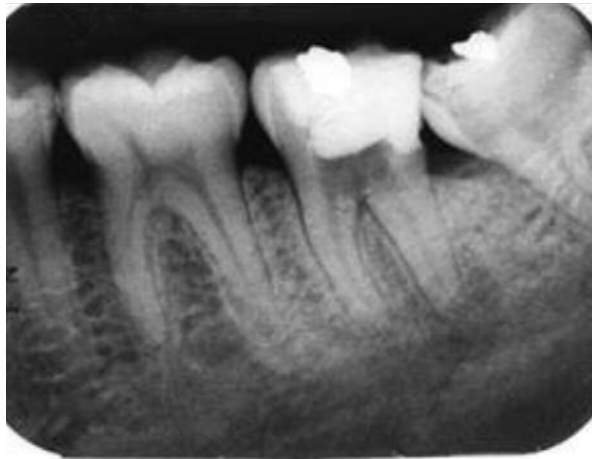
Tooth 37 showing periapical radiolucency with furcal perforation.
